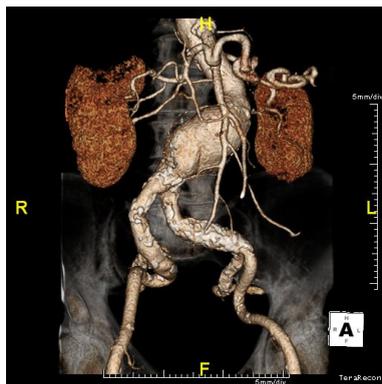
Computed tomography angiography depicting an infrarenal abdominal aortic aneurysm
